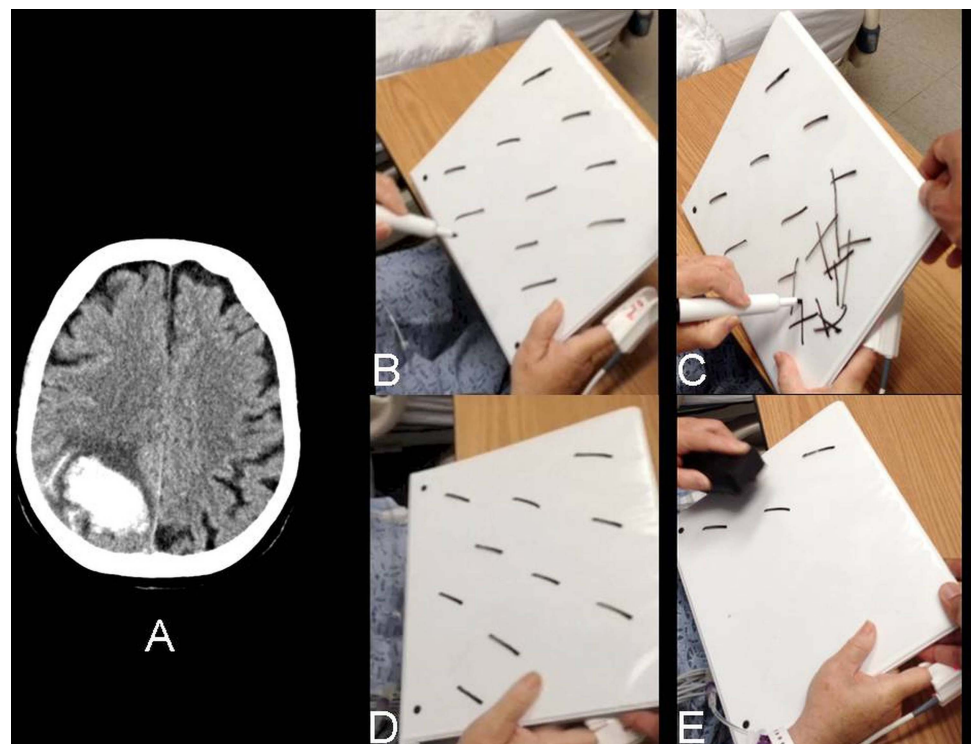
Standard and modified target cancellation tasks in hemispatial neglect. (A) CT scan of head showing a right parietal haemorrhage. (B, C) Standard target cancellation task. (D, E) Modified target cancellation task, in which the patient erases each line that is detected. See the online supplementary video. Used with permission from Modern Neurology.
